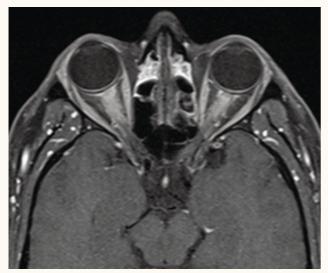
This male in his mid-30s presented with severe eye pain bilaterally that was worse on eye movement. A CT scan was completed during the initial visit due to suspected myositis but was unremarkable. The patient returned to the emergency department three days later with a sudden and drastic decline in his visual acuity from 20/15 in each eye at the initial visit to no light perception in the right eye and 20/400 in the left eye. An MRI obtained that day (seen here) revealed bilateral ON. Labs eventually returned with elevated anti-MOG antibody titers.
